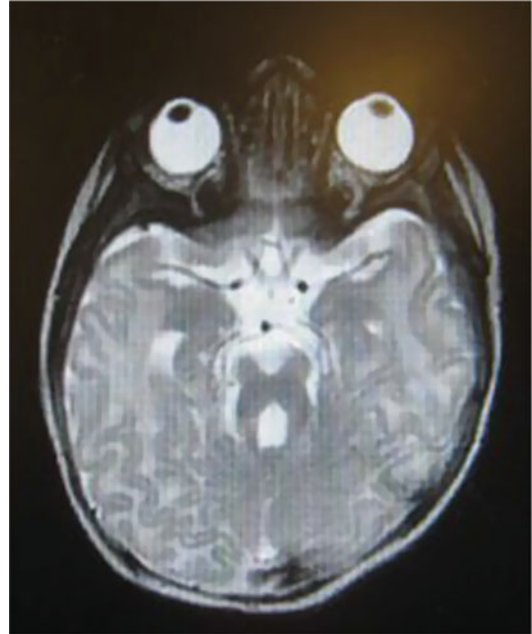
MRI of the brain showed hypoplasia of cerebellum with "molar tooth sign" leading to diagnosis of Joubert syndrome
